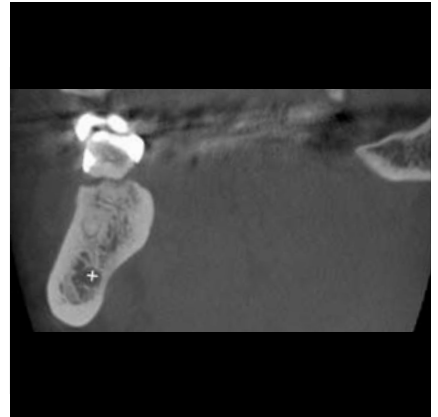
Coronal CBCT image with mandibular canal (*)
